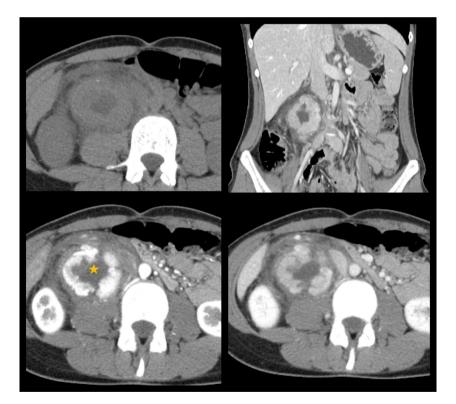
Abdominal CT, from left to right, top to bottom: unenhanced scan, contrast-enhanced scan in portal phase on the coronal plane, arterial phase, portal phase. A hypervascular mass is seen displacing the right kidney, with a hypodense center (*), compatible with necrosis.
